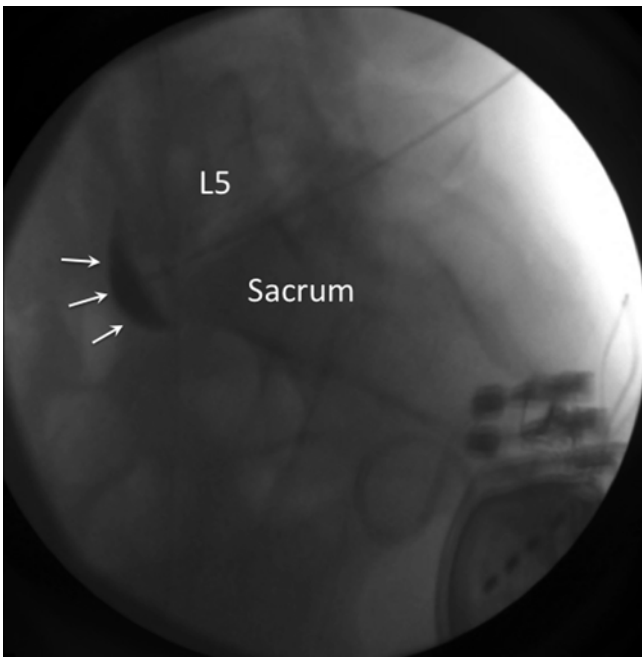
Lateral radiograph of the lumbosacral junction. The contrast was outlined by the line *arrows* (With permission from Philip Peng)
